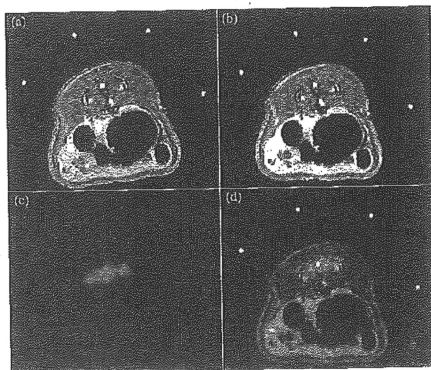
Typical superimposed image using MR and PET images. MR images (a) before and (b) after registration, (c) PET image and (d) superimposed image between MR and PET images after registration. The signals from a PET image at the spinal column and iliac bodies closely conformed to the signal from MR images. PET data are shown in color.
